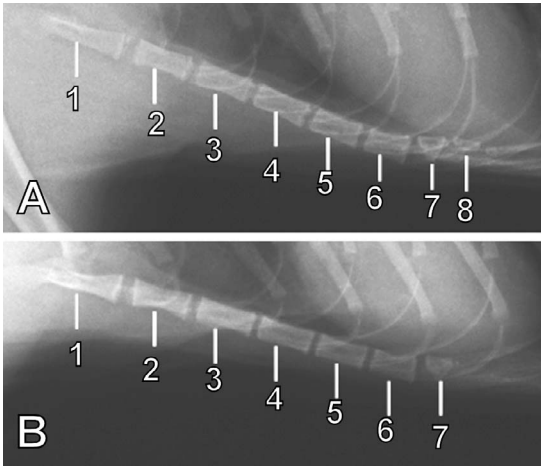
Close-up of right lateral thoracic radiographs of the sternum of 1.4-yr-old male (5.6-kg) (A) and female (4-kg) (B) red pandas. Note the visibility of a small mineralized xiphoid process in (A) and lack of visibility of the mineralized xiphoid process in (B). Manubrium sterni (1), second sternebra (2), third sternebra (3), fourth sternebra (4), fifth sternebra (5), sixth sternebra (6), seventh sternebra (7), and xiphoid process (8).
